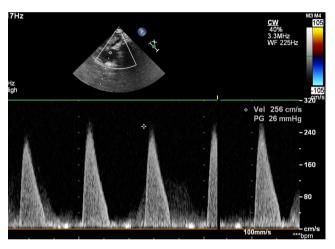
Doppler showing gradients of 26 mm Hg across narrowed supravalvular region.
